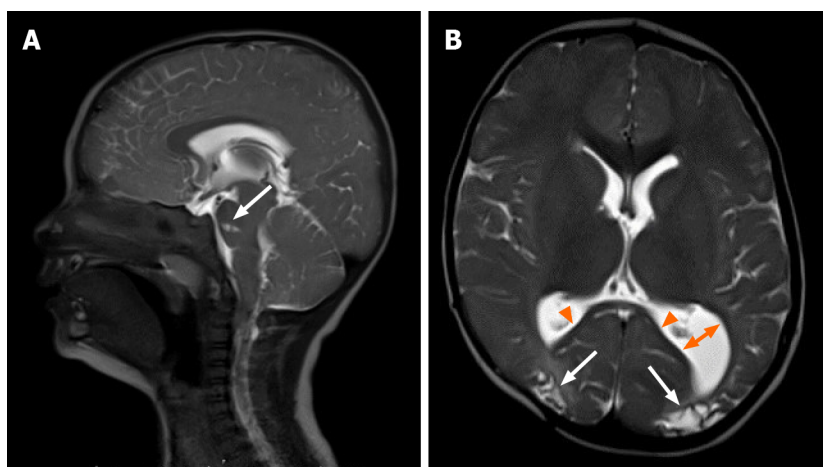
Follow-up magnetic resonance imaging at 15 mo. A: Follow-up magnetic resonance imaging at 15 mo demonstrates continued resolution of the subdural hematomas and obstructive hydrocephalus on sagittal T2. Note the focal encephalomalacia at the pons (arrow); B: Axial T2 demonstrates encephalomalacic change manifested by thinning of the posterior corpus callosum (arrowheads), decreased gray and white matter of the posterior occipital regions bilaterally (arrows), and colpocephaly of the left lateral ventricle (two direction arrow).
